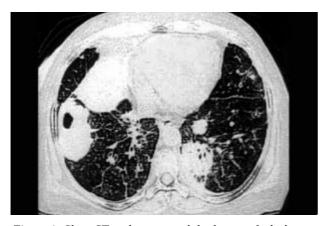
Chest CT, pulmonary nodules largest of which measuring 7 cm
